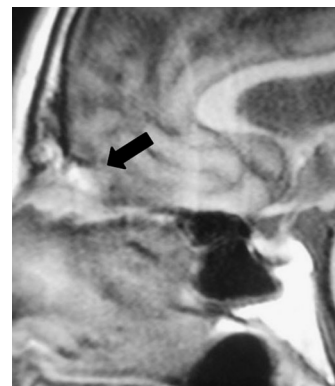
Sagittal MRI. Black arrow indicates a tumefaction, which seems to be related to the brain rather than to the nose.
